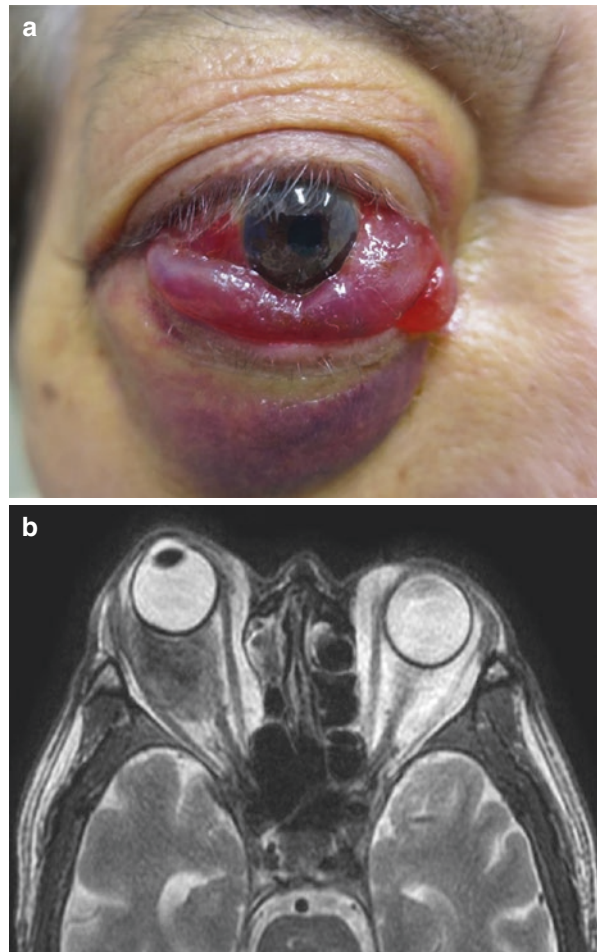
Clinical and radiographic presentation of retrobulbar DLBCL. (a) The clinical appearance showing prominent exophthalmos and conjunctival edema with visual acuity loss. T2-weighted axial (b) and coronal (c) magnetic resonance imaging scans shows that the orbital mass causes proptosis
